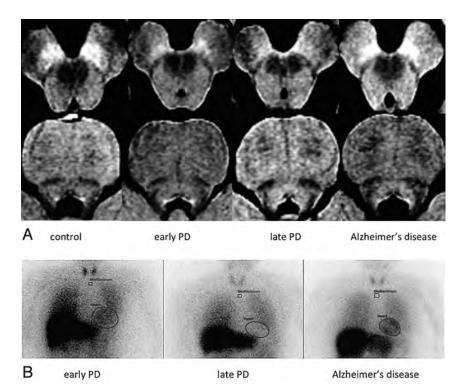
Findings of neuromelanin MRI and ¹²³I-metaiodobenzylguanidine scintigrams of patients and control subjects. *A*, NmMRI: Signals are reduced in NmMRI of substantia nigra pars compacta and locus ceruleus according to Parkinson disease stage. *B*, MIBG scintigraphy: MIBG scintigrams show PD stage-dependent cardiac MIBG reduction.
